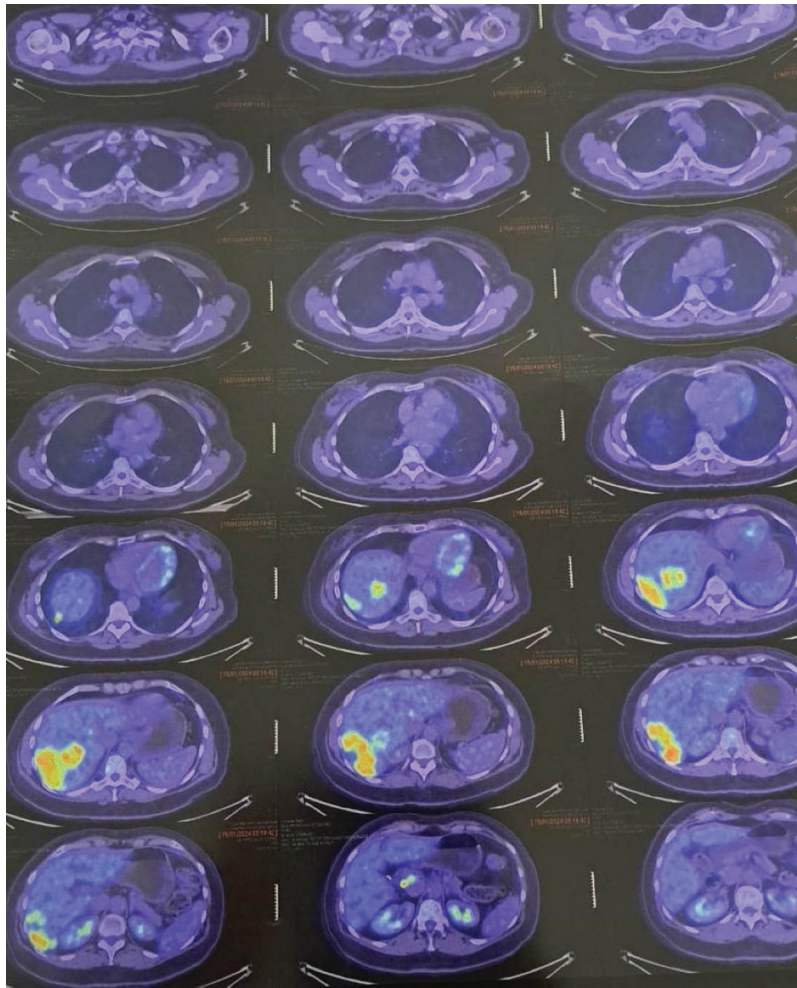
The positron emission tomography-computed tomography scan with the presence of hyperuptake of liver lesions in segments VI and VII.
